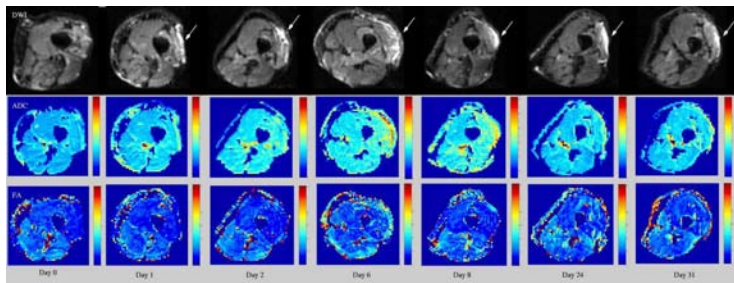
Axial images of human thigh muscles obtained before and immediately after biopsy, and days 2, 6, 8, 24, 31 post-biopsy. Top row: DWI images; middle row: ADC maps; bottom row: FA maps. The arrows (high intensity on DWI images) indicate site of biopsy.
